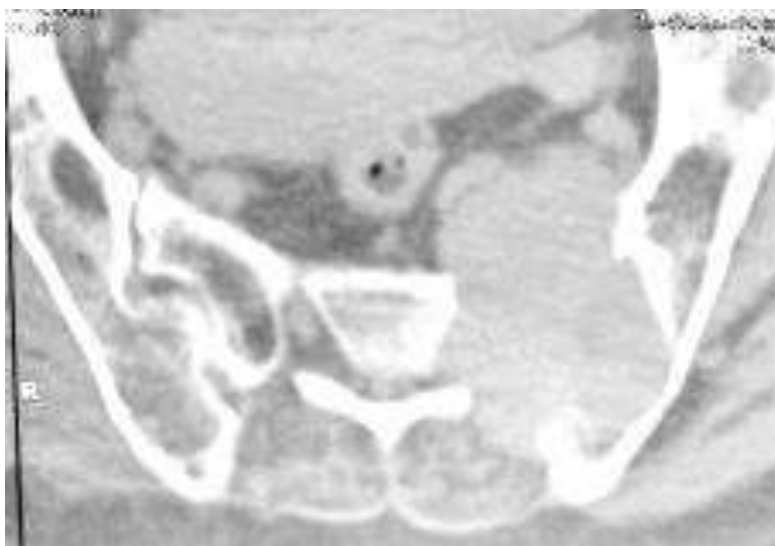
CT Show Left Osteolytic Sacral Lesion of 4.5 × 3.5 × 6 cm S1, S2, and S3 Vertebral Involvement.
